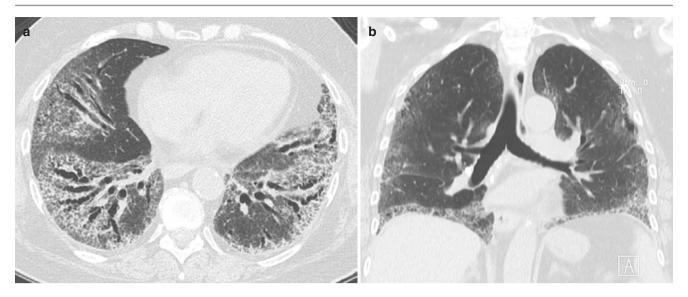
Taxol-/carboplatin-induced NSIP. (a, b) Axial and coronal CT images show lower lung predominant GGOs and traction bronchiectasis with peribronchial distribution. Note subpleural sparing in right posterior lung and striking volume loss in lower lobes
